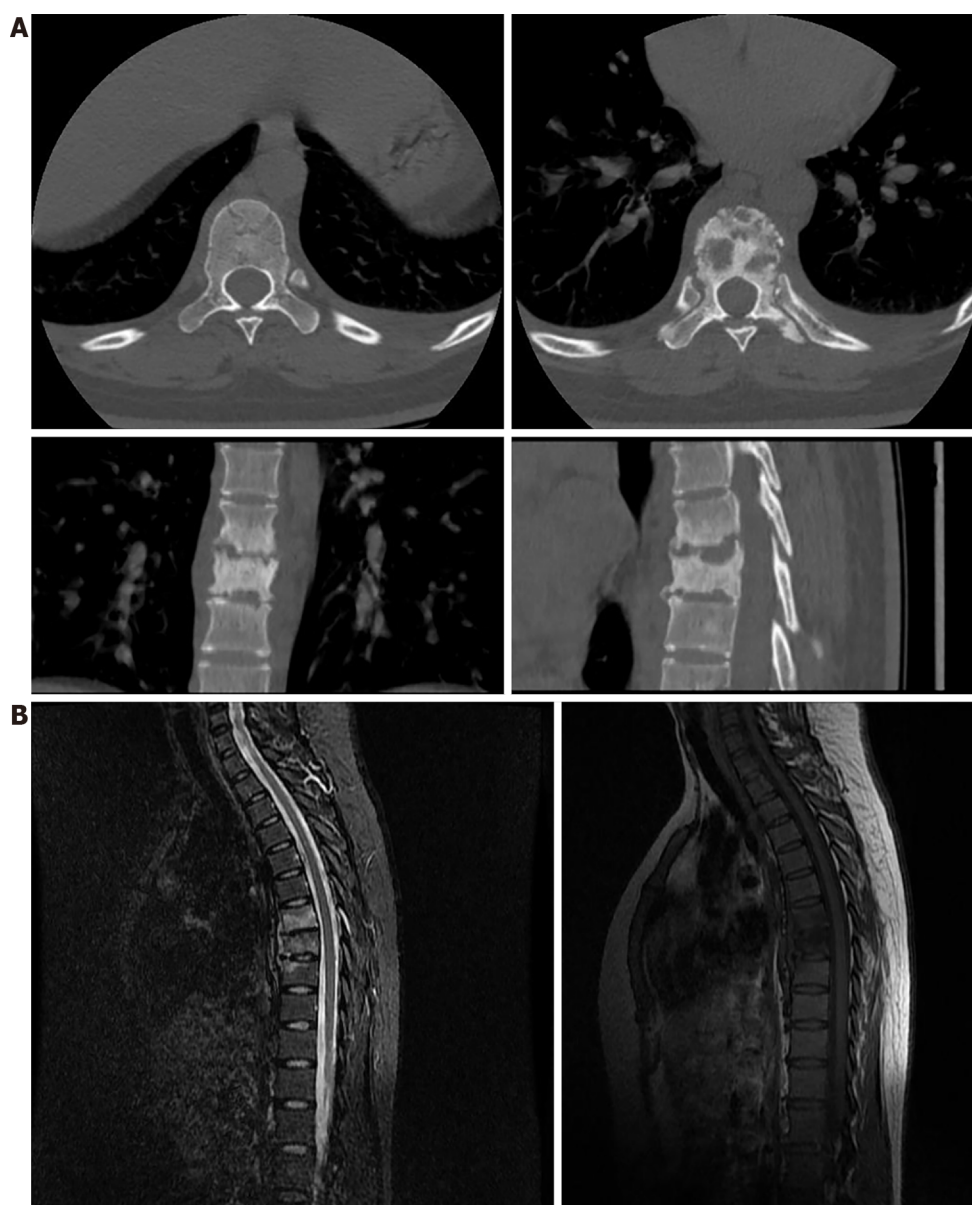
Computed tomography and magnetic resonance imaging of the thoracic spine. A: Thoracic vertebral computed tomography shows bone destruction in T7-9, with T8 being the most significant; B: Magnetic resonance imaging of the thoracic vertebra showed signs of bone abnormalities in T7-9, with T7 and T8 being the most significant.
